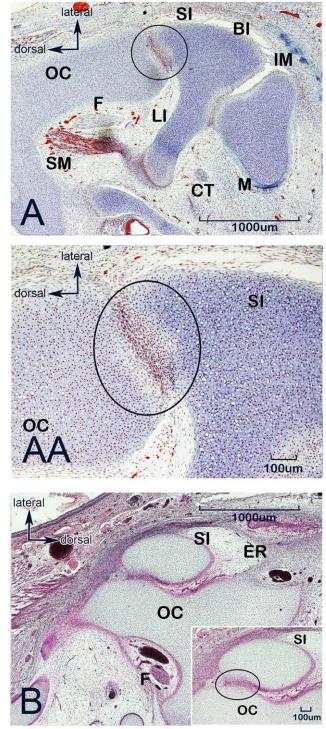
Initial disconnection phase of the incus to the otic capsule. Formation of interzone between otic capsule and incus. 9–11 WD. Human foetus of 41.5 mm GL (9 WD). Horizontal section. (Panel A,AA). The Panel (AA) is an enlargement of Panel (A). Interzone (surrounded by oval) between the otic capsule (OC) and short limb of the incus (SI). The cavity of the incudomalleolar joint (IM) was larger than 8 WD. Human foetus of 62 mm GL (11 WD). Horizontal sections (Panel B). Interzone (surrounded by oval) between the otic capsule (OC) and the short limb of the incus (SI) was located dorsally to the facial canal and facial nerve (F), in the future fossa incudis of the epitympanic recess (ER). BI, body of the incus; CT, chorda tympani; LI, long limb of the incus; M, malleus; SM, stapedius muscle.
